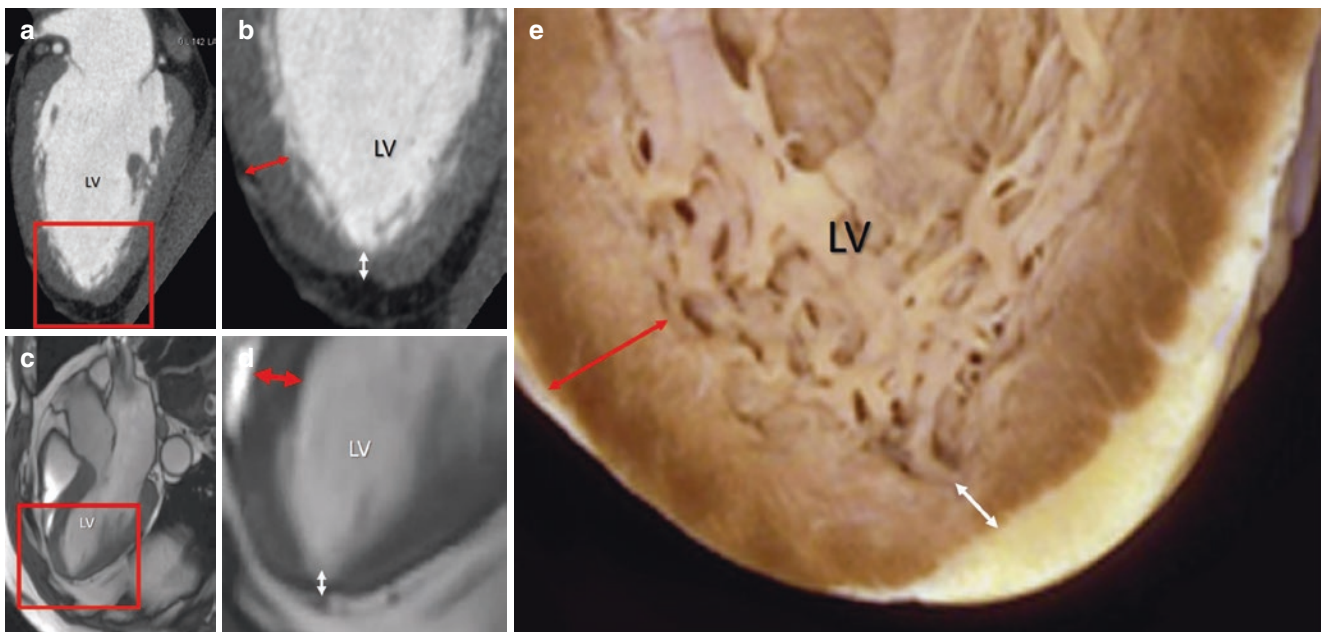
(a) Computed tomography planar image in two-chamber view and (c) cardiac magnetic resonance in long-axis view. The areas in red boxes are magnified in (b) and (d) respectively. Both techniques beautifully visualized as the tip of apex is thinner (*white double arrow*) than
